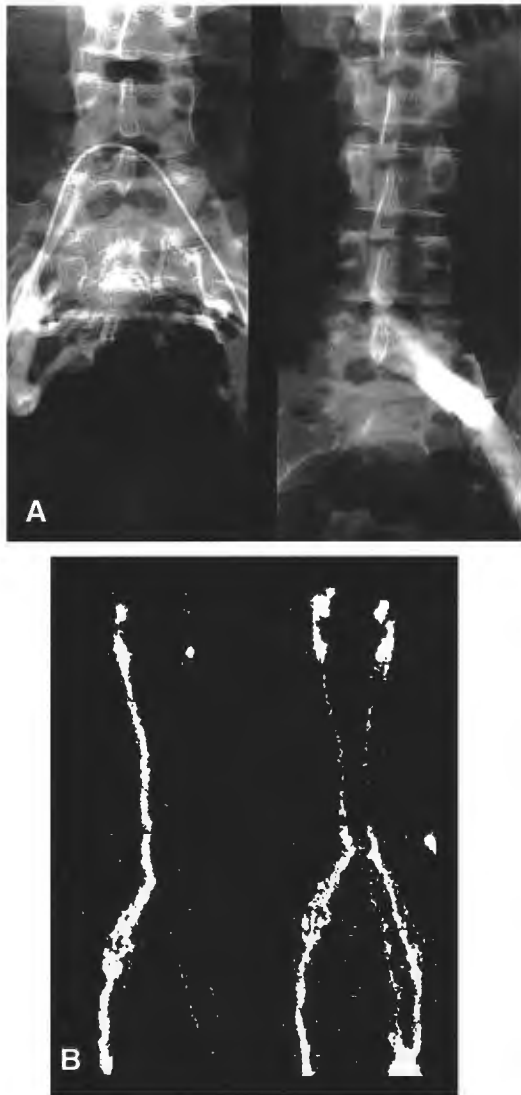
Preoperative and postoperative transfemoral venograms. A, correction of iliac venous stenosis by a long 16-mm stent. B, normalization (*right panel*) of previously absent (*left panel*) lymphoscintigraphic nodal activity after stent placement.
